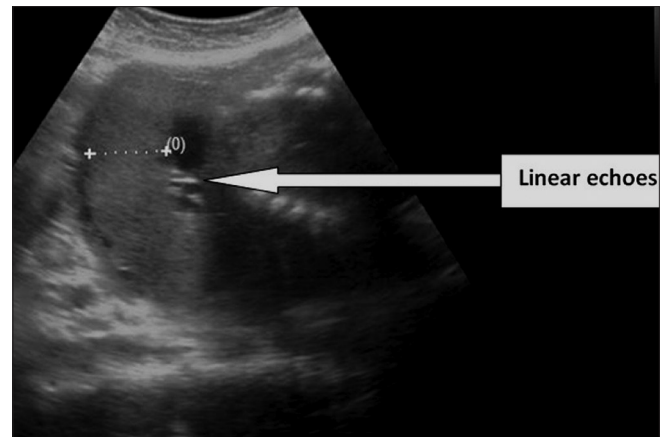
Grey scale obstetrics sonogram showing the measurement of fundally located placental thickness (in between calipers) measured from the chorionic plate to the basal plate at the level of umbilical cord insertion site (linear echoes emanating at right angles from the placental surface)
